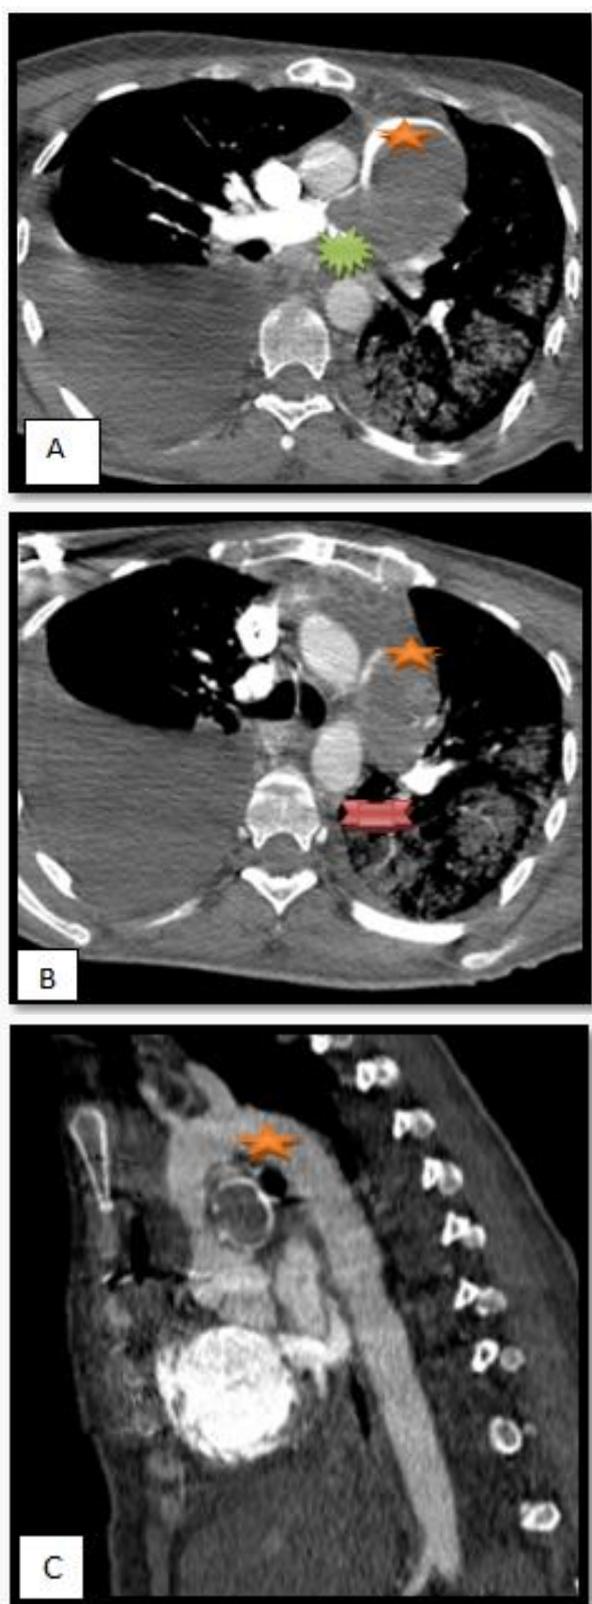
(A) and (B) axial, (C) sagittal and (D) coronal Computed tomography images: pulmonary artery the site of a tissue like material hypodense, involving the pulmonary artery trunk , and extending to the origin of the left  and right  pulmonary artery.
